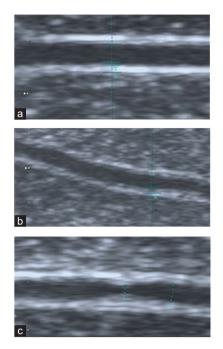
Ultrasound images of a "healthy cavernous artery" and of a "cavernous artery disease." (a) Normal cavernous artery; (b) intima-media thickness (IMT ≥ 0.3 mm); (c) cavernous artery plaque. IMT: penile intima-media thickness.
